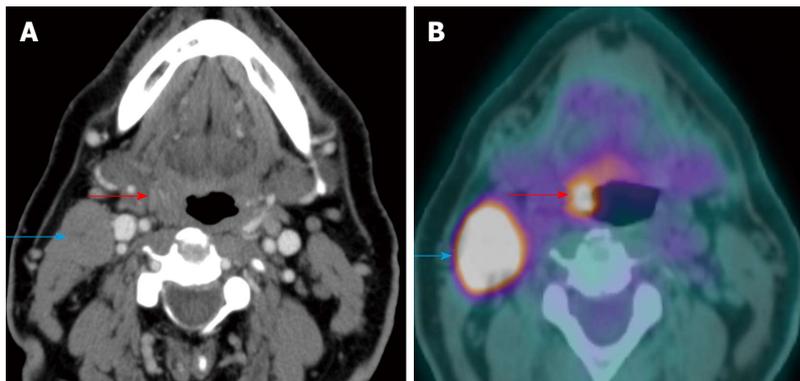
Carcinoma of unknown primary. The patient presented with palpable right level II a lymphadenopathy (blue arrows). Fine needle aspiration of the lymph node was positive for squamous cell carcinoma. Panendoscopy without biopsy and contrast-enhanced computed tomography (CT) (A) were unremarkable. Positron emission tomography/CT (B) showed a small hypermetabolic area in the right palatine tonsil (red arrows) proven to be squamous cell carcinoma by biopsy.
